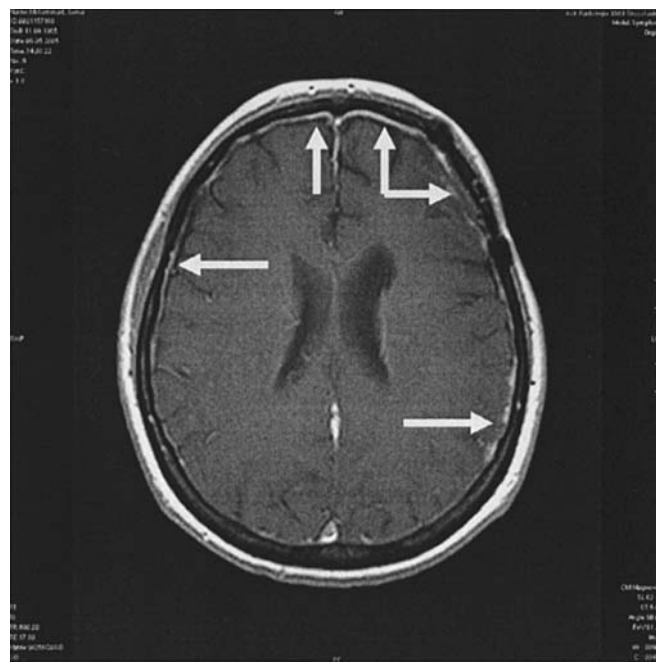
MRI post contrast scan: progressive meningeal enhancement (June 2005). Arrows indicate progressive meningeal enhancement.
